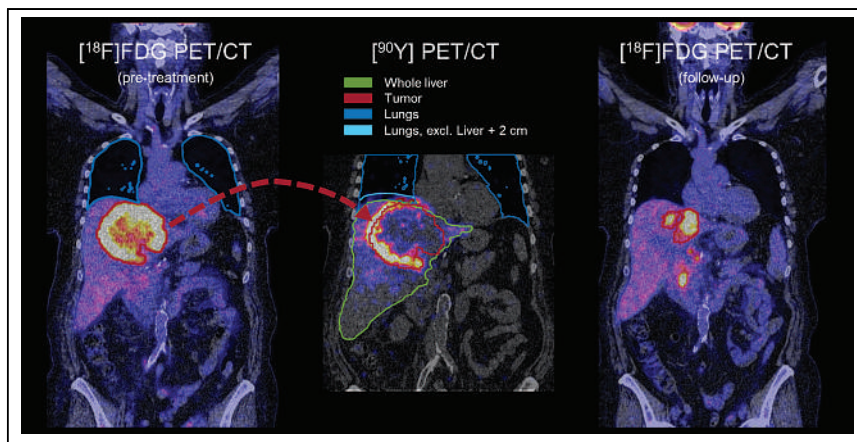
VOIs: tumor (red) segmented by $[^{18}\text{F}]\text{FDG}$ PET/CT thresholding, transferred to ^{90}Y PET/CT (or ^{166}Ho SPECT/CT). Lungs (blue) are segmented by thresholding of associated CT of $[^{18}\text{F}]\text{FDG}$ PET/CT for lung volume measurement and by associated CT of ^{90}Y PET/CT (or ^{166}Ho SPECT/CT) for dosimetry where lung portions within 2 cm of liver boundary are excluded (light blue). Liver (green) and treated liver (in this example same as liver) are manually delineated on associated CT. For response assessment, tumor (red) is segmented by $[^{18}\text{F}]\text{FDG}$ PET/CT thresholding (follow-up).
